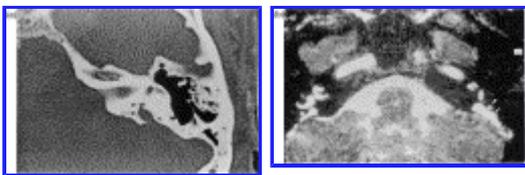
Congenital anomaly. (a) CT; (b) T2-gradient echo MR. Asymmetric dilatation of the endolymphatic sac and duct (arrow). Associated dilatation of the right vestibule and of the common crus between the anterior and posterior semicircular canals.
